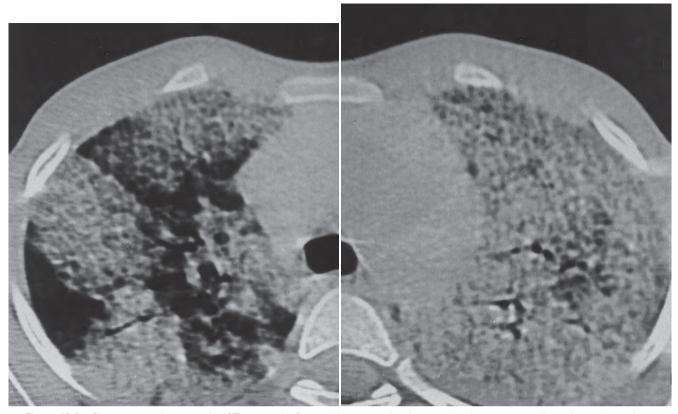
Chest computed tomography (CT) scan in the 9-year-old patient with pulmonary alveolar proteinosis whose chest radiograph is shown in Figure 48-1.
